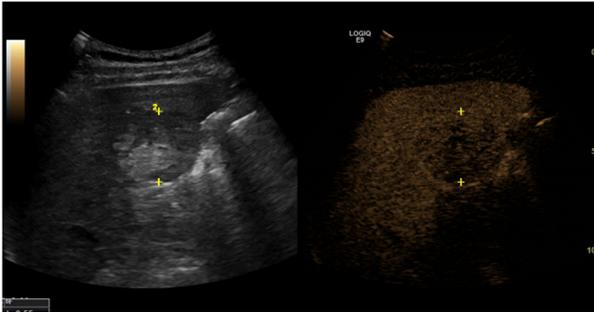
Ultrasound with contrast substance. Late phase: slow wash-out specific for HCC
